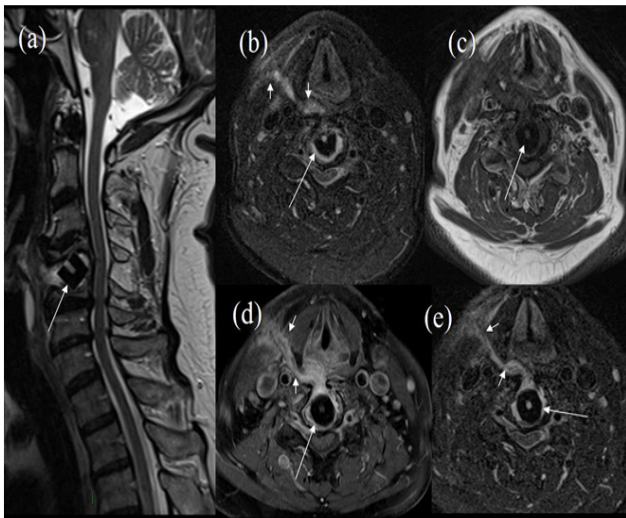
Initial MRI. (a) T2 axials showing rotated disc implant (white arrow) surrounding by fluid. (b) STIR axials, (c) T1 axial and (d,e) Post contrast T1 fat suppressed axials, showing Implant (long white arrow) and the sinus tract (short white arrows). In (b), the sinus tract shows as high signal on STIR (short white arrows). In (d,e), there is enhancement along the sinus tract (small white arrows).
